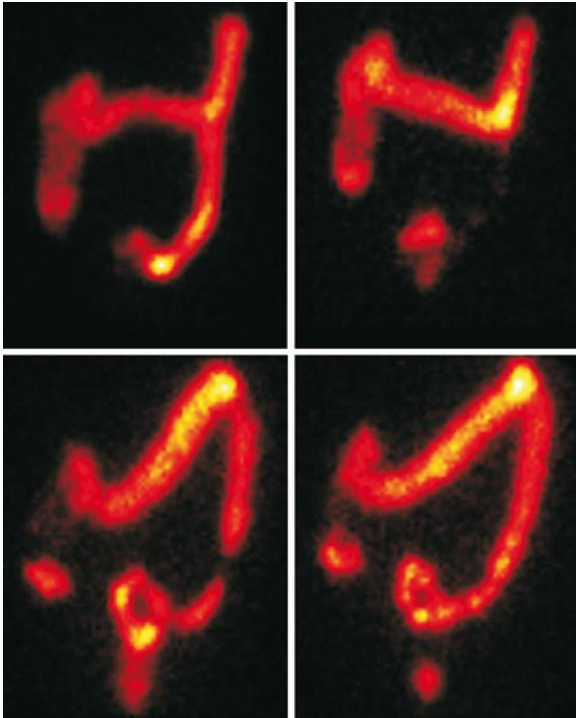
Colorectal transport: scintigraphy before (left) and after (right) defaecation. Normal (*top*) and in a patient with sacral spinal cord lesion (*bottom*)
